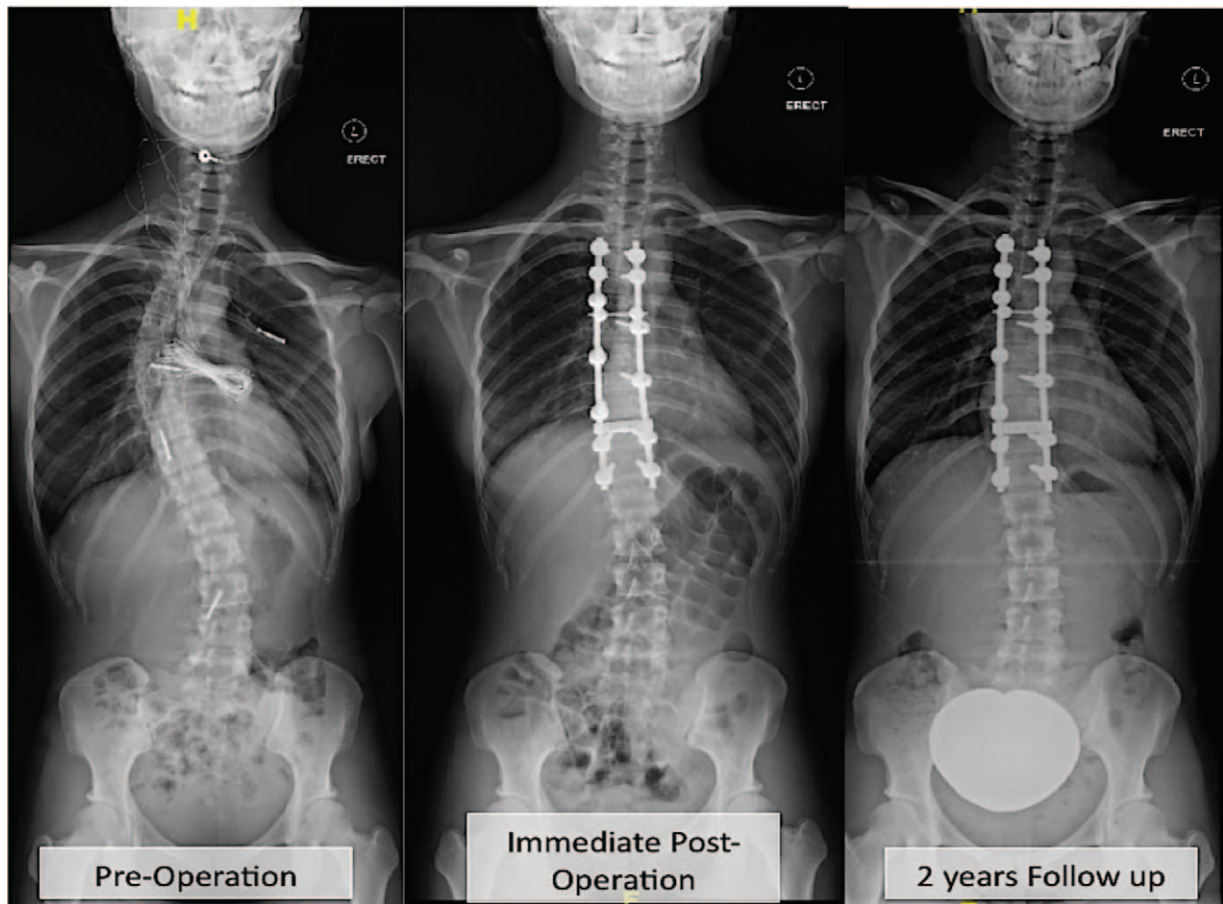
Preoperation, immediate postoperation, and 2 years postoperation radiographs showing no loss of correction or instrumentation failure.
